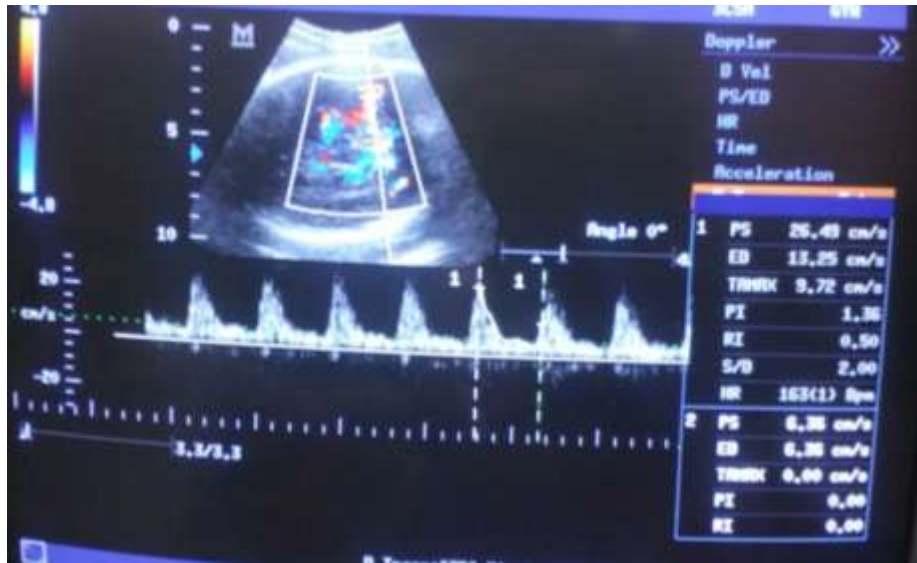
shows color Doppler middle cerebral artery waveform at 36
